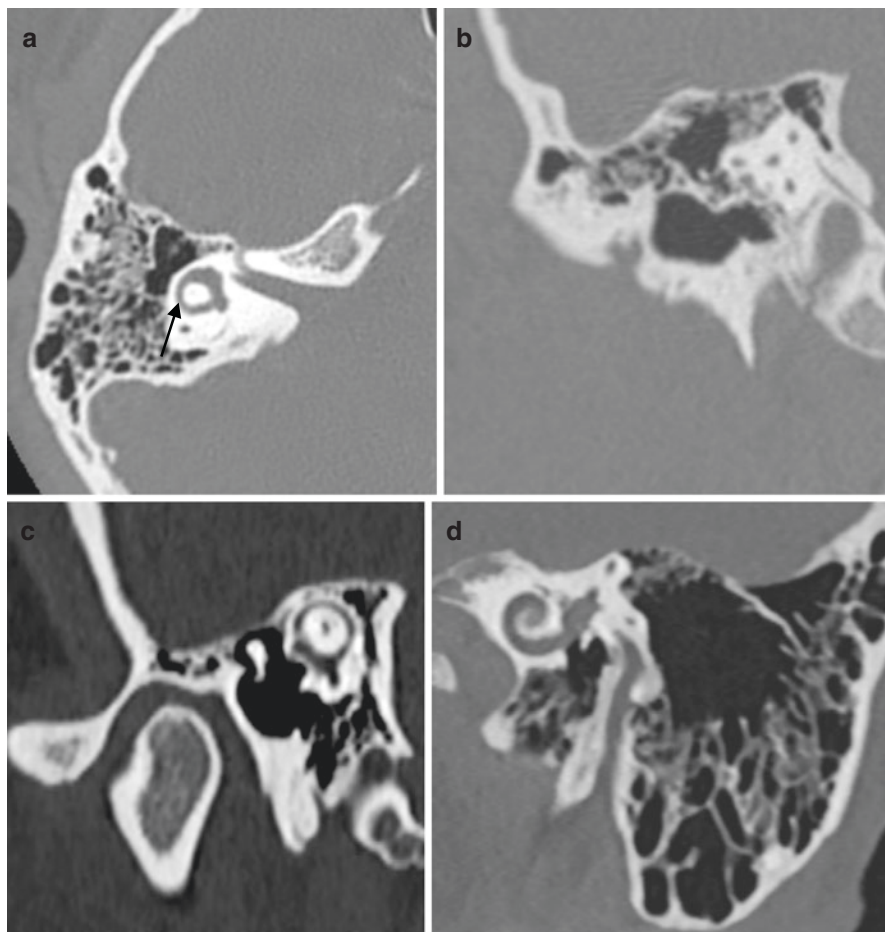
(a) Images are in plane with the lateral semicircular canal (arrow). Normal CT scan. (b) Coronal image perpendicular to horizontal semicircular canal. (c) Pöschl View of the superior semicircular canal. (d) Stenver projection
